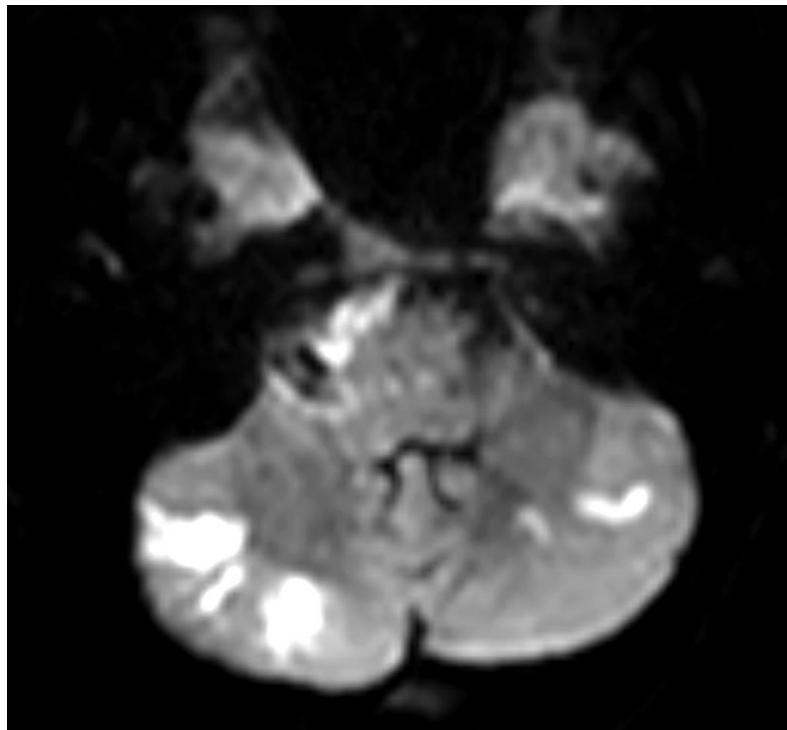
MRI showing diffusion restricting lesions in the cerebellum
